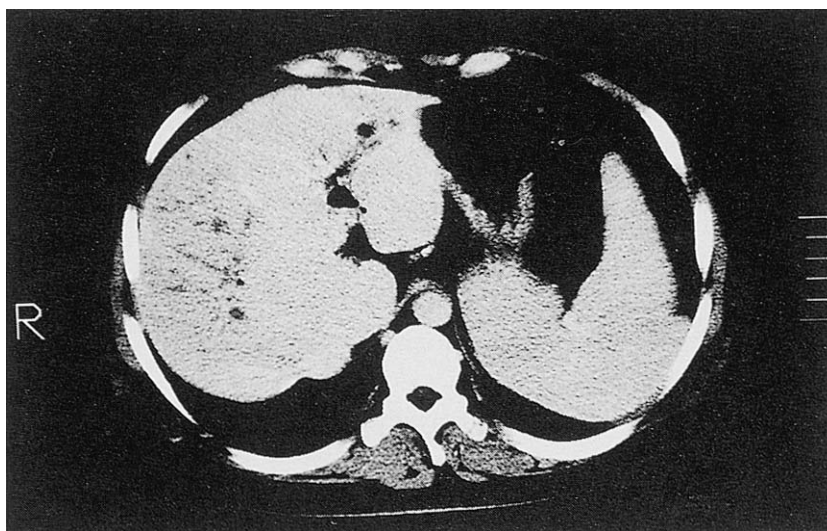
A 21 year-old female who frequently suffered from recurrent cholangitis, jaundice, and/or gastrointestinal bleeding from esophageal varices. CT images revealed atrophy of the right liver lobe, dilatation of IHBD, and splenomegaly.
